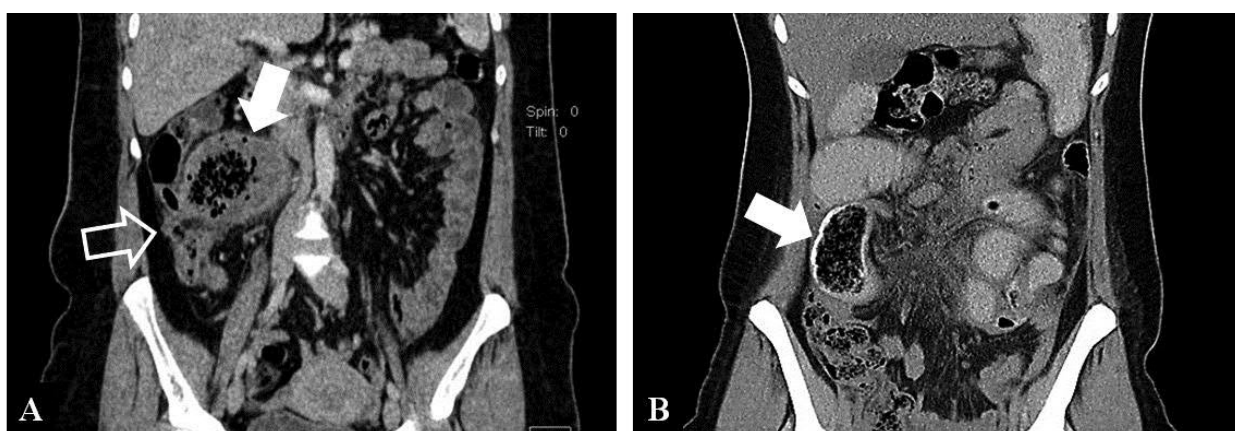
CT diagnosis of the hollow organs fistula, caused by textiloma
